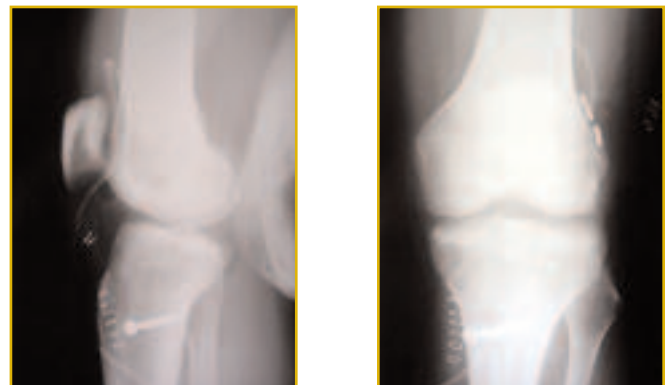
Immediate post op. Xray showing the tunnels, femoral and tibial graft fixation
